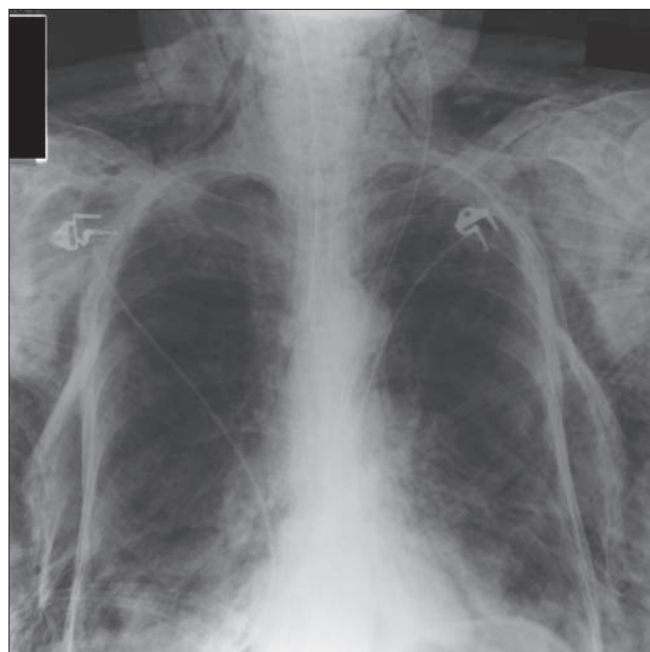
Portable chest radiograph showing significant subcutaneous emphysema obscuring visualization of the left-sided pneumothorax.
